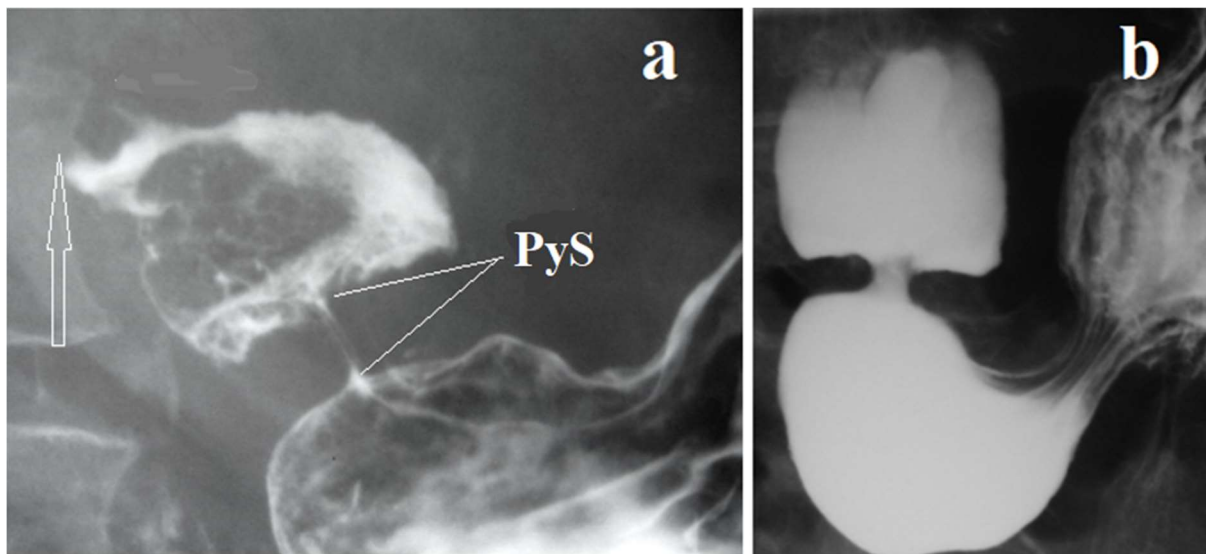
Radiographs of the gastroduodenal junction. (a) The PyS is in a closed state. The arrow indicates the location of the contracted post bulbar sphincter. The width of the bulbous base is almost equal to that of the opposite side of the stomach. (b) In the horizontal position, the moment of the evacuation of barium from the stomach is visible, the PyS widened, and its length decreased. The width of the base of the bulb is almost equal to the part of the stomach facing it. (The figure shows radiographs of elderly people examined for problems of the digestive tract. Therefore, the size of the pyloric canal cannot be considered normal).
